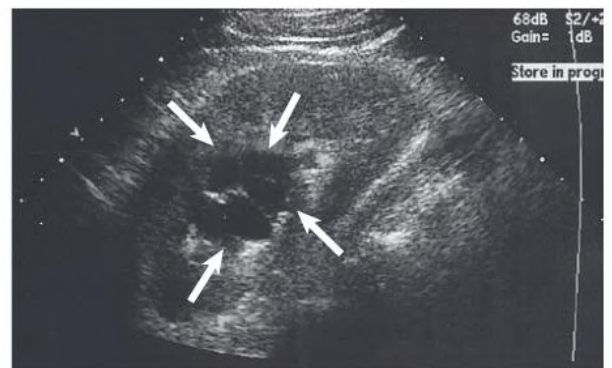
Sagittal ultrasound image of a complex kidney cyst (arrows).
